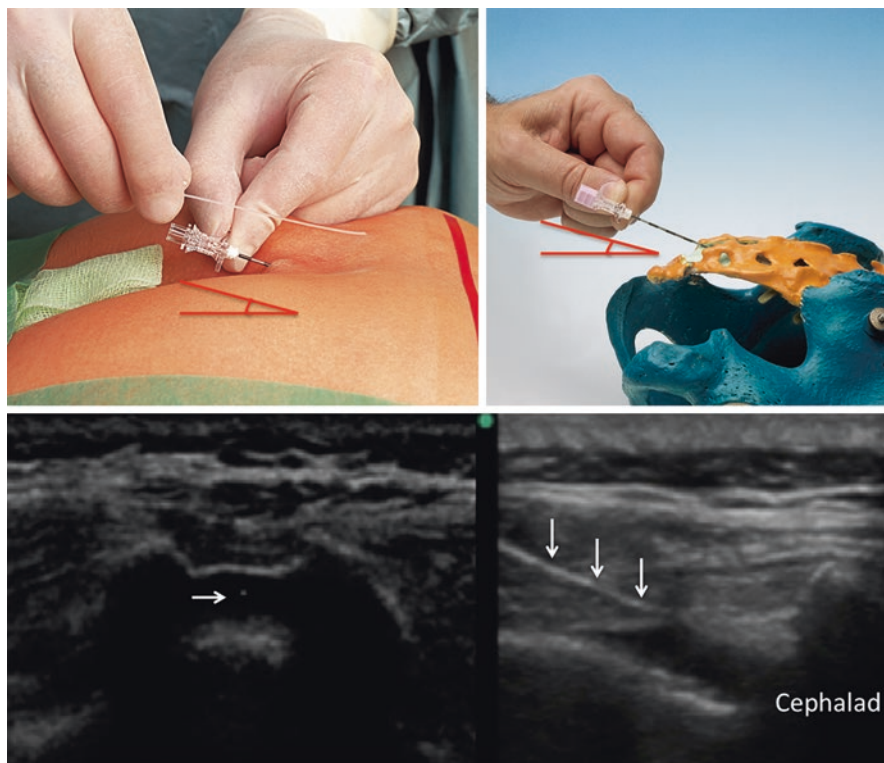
Upper panel. The steep angle of entry to caudal canal. Lower panel. Sonographic images of the needle in short axis (left lower) and long axis (right lower). (Reproduced with permission from Philip Peng Educational Series)
